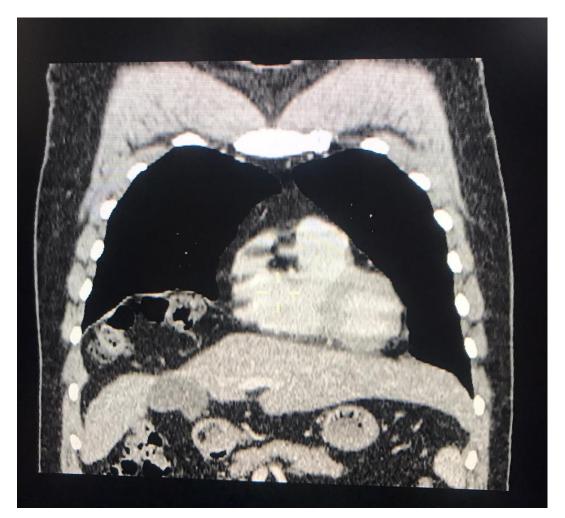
Thorax CT scan - Coronal view – the anterior interposition of colonic loops between the right hemidiaphragm and liver
